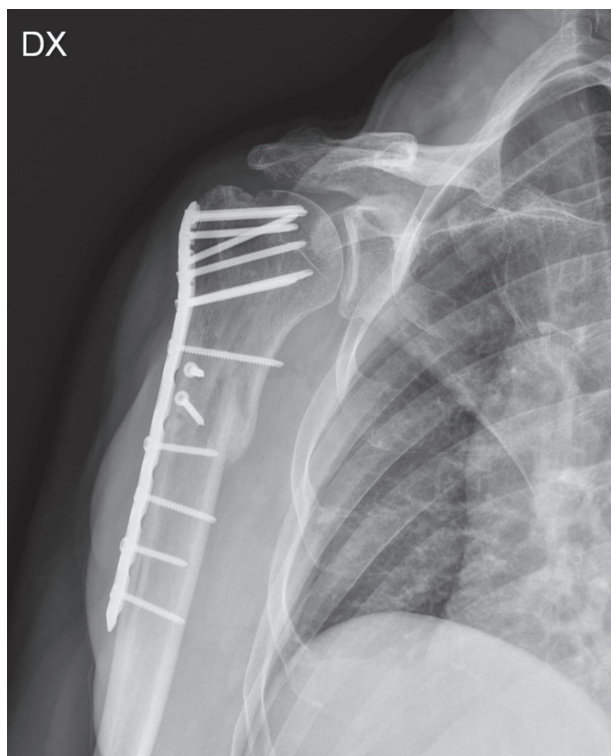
Four months follow up x-ray (AP view)
